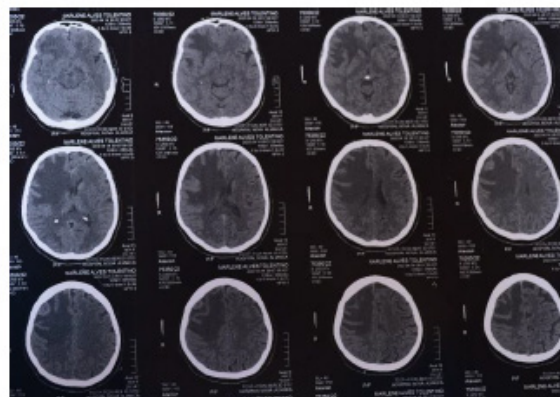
Emergency head CT, with the following aspects observed: spontaneously hyperattenuating nodular lesion centered in the middle frontal gyrus on the right, measuring 2.0 x 1.9 x 2.0 cm in the presence of a hypoattenuating area with a permeative aspect predominantly involving the subcortical zone between the white and gray matter (probable vasogenic edema), with an expansive effect that partially erases convexity grooves in the ventricular system, requiring evaluation with intravenous contrast, preferably MRI, for additional information.
